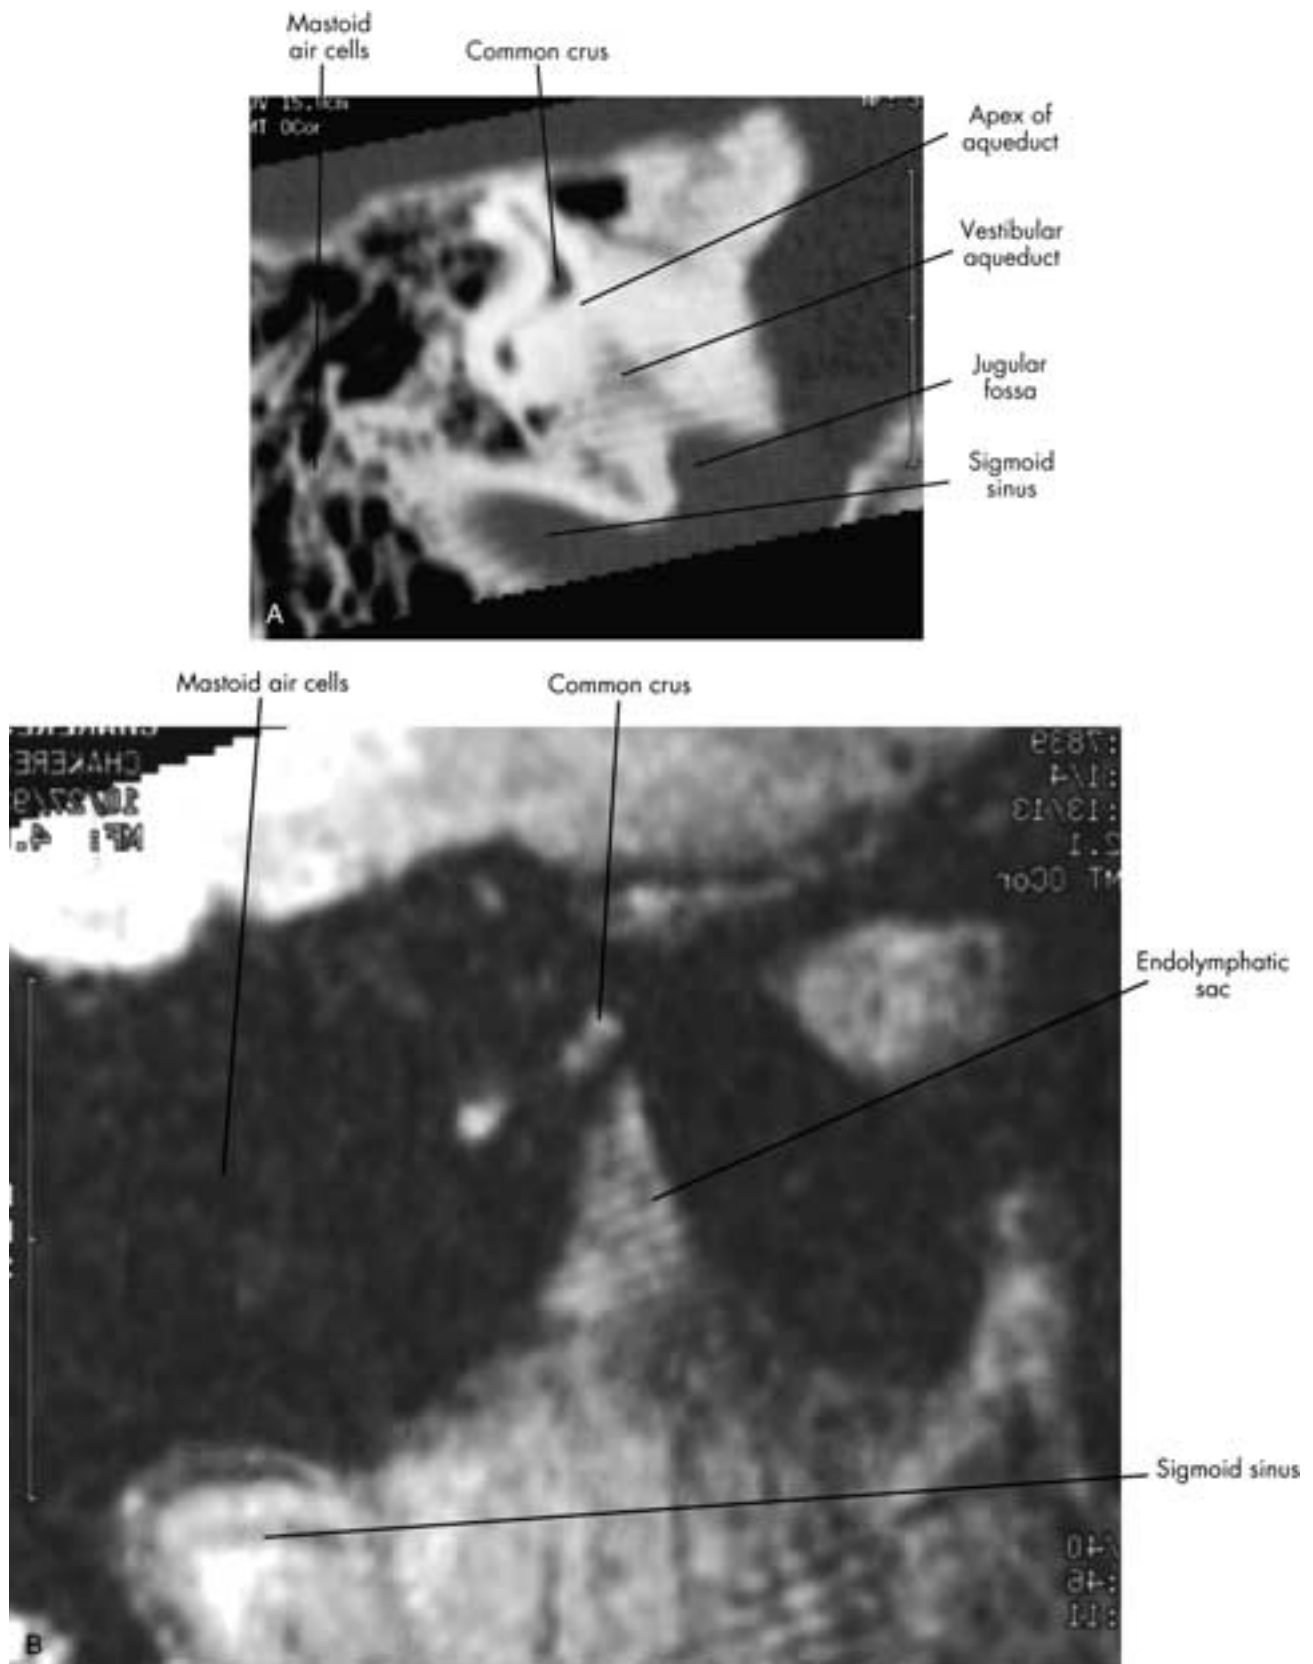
Double oblique MR imaging and CT, endolymphatic sac. A, Reconstruction of axial CT images. This is a double oblique section completely paralleling the flat plane of the endolymphatic sac. The sac is triangular in shape, similar to a Christmas tree, with the apex pointing at the common crus. The base of the sac broadens inferiorly. B, The identical projection on a different patient generated from 60 free precession 3DFT MR image series. This type of presentation of the endolymphatic sac is easier to analyze than the multiple short segments seen on routine imaging.
